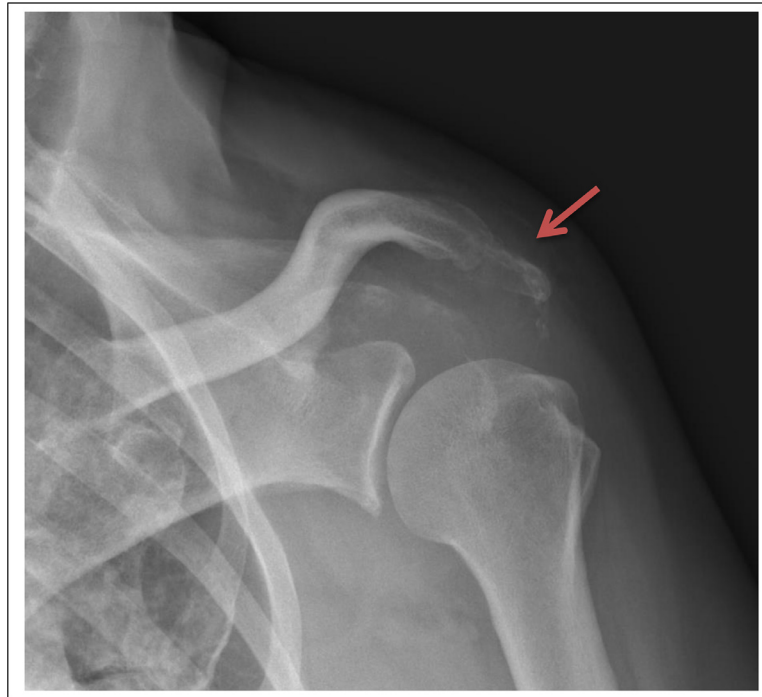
Shoulder X-ray with heterogeneous calcified soft tissue around the acromio-clavicular joint (arrow) and also clavicular and acromial lucencies.
